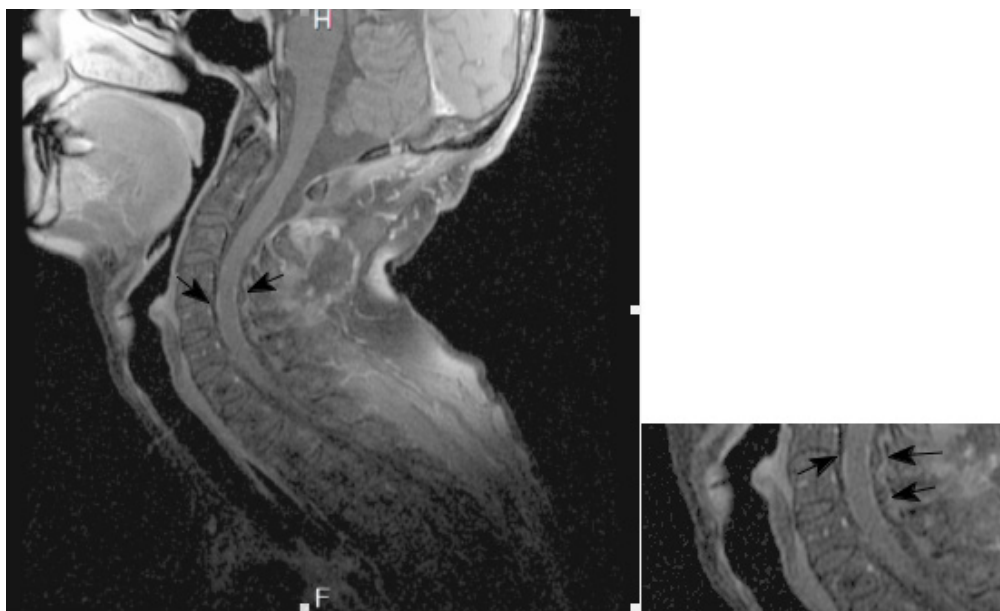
A/SAG T1 FLAIR MRI of cervical spinal axis after 4 months of RT and 3 months of targeted therapy alone.
